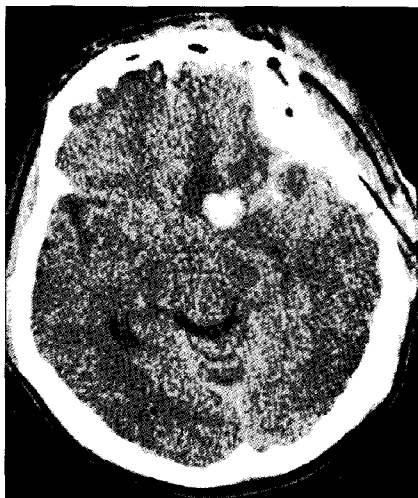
Brain computed tomographic scans on the third postoperative day demonstrates delayed development of epidural hematoma, small amount of subdural hemorrhage over the distal sylvian fissure and small amount of intracerebral hematoma in frontal lobe.
